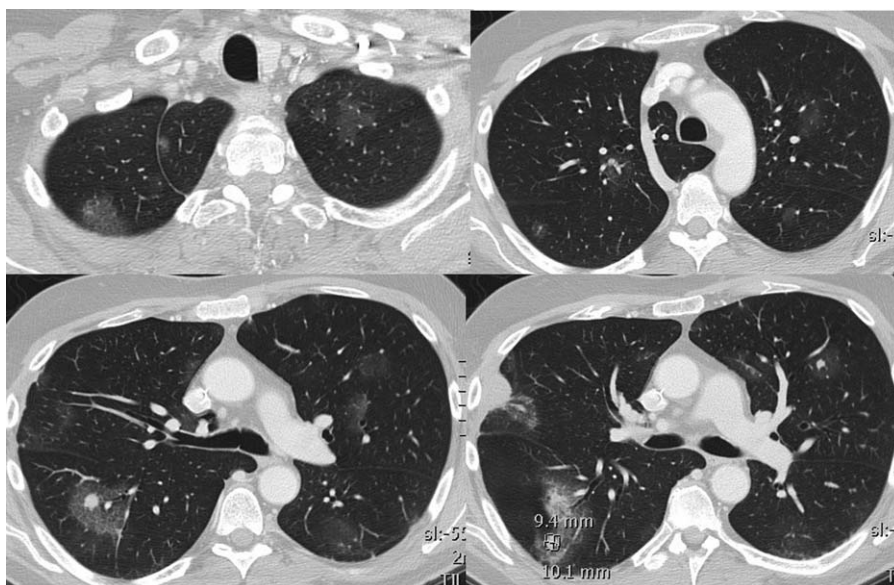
Patient 2. CT shows bilateral pulmonary metastatic lesions characterized by nodules with halo sign (the biggest measuring about 1 cm) and ground glass lesions.
